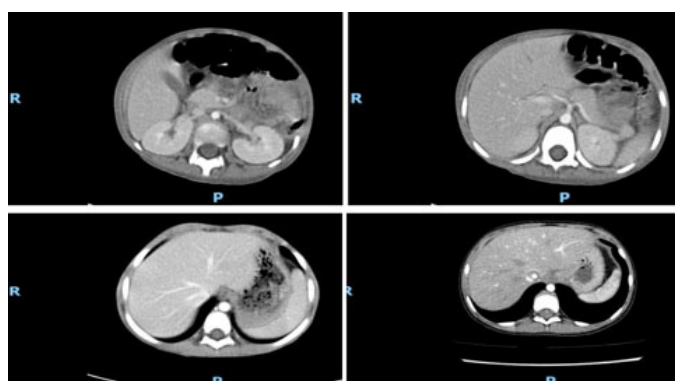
CT scan showing interval resolution of the mass during the follow-up period. Initial presentation on the upper left image. Follow-up after 3 years, image on lower right. In-between CT images are at 1 and 2 years follow-up.
